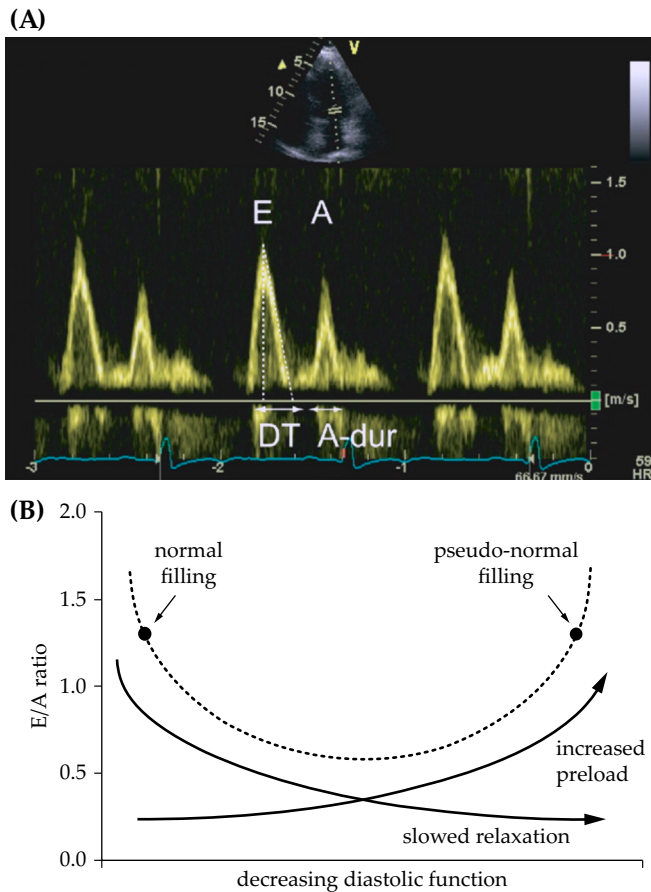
An example of normal transmitral blood flow velocity measured with a pulse-wave Doppler system. Note the peak amplitude of the E and A waves, DT and A-dur (panel A). The E/A ratio is used for evaluating diastolic abnormalities, when pseudonormal results might be the result of increased left atrial pressure due to progressive diastolic dysfunction (panel B). Adapted from Claessens *et al.* [127].
